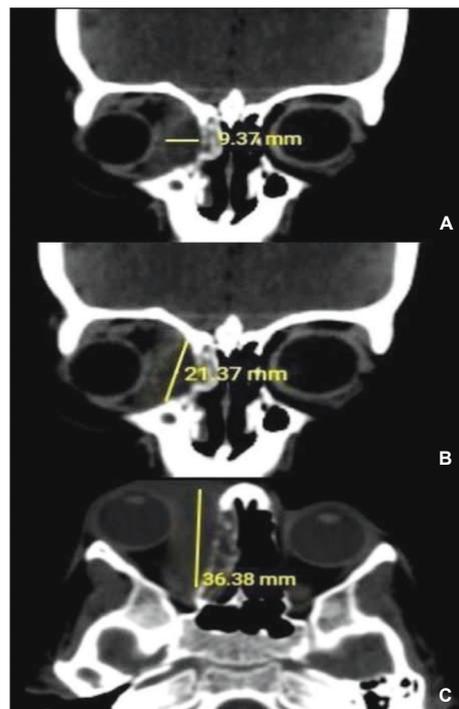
Measurement images of the right medial SPOA in CT slices, A) Measurement of the width of the right medial SPOA in coronal section CT, B) Measurement of its height in coronal section CT, C) Measurement of the length of the SPOA in axial section CT.
